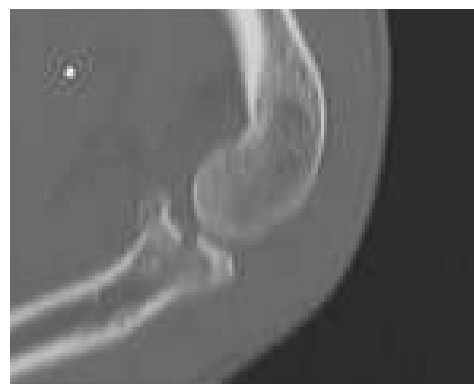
Sagittal CT image reveal a displaced radial head fracture
